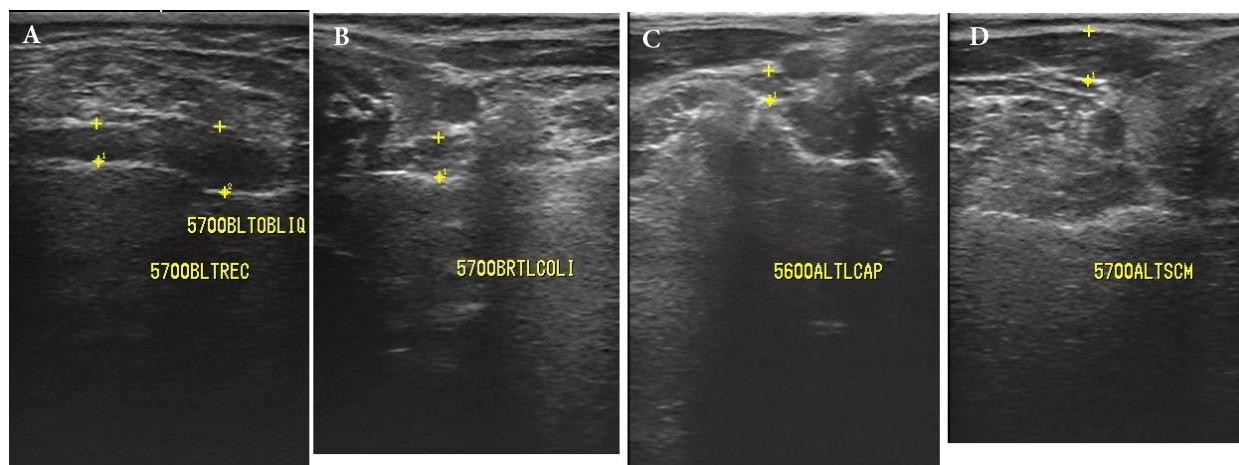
Ultrasonographic images of the rectus capitis posterior (A), Oblique capitis superior (A), longus colli (B), Longus capitis (C), and sternocleidomastoid (D) muscles (REC, rectus capitis posterior; OBLI, oblique capitis superior, LCOLI, longus colli, LCAP, longus capitis ; SCM, sternocleidomastoid)
